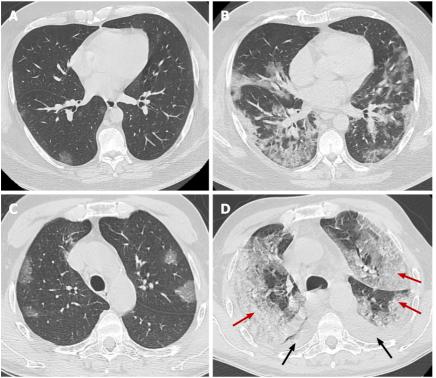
Axial computed tomography images in two different patients 5 days after onset of symptoms show various degree of groundglass opacities abnormalities (early stage of COVID-19).
